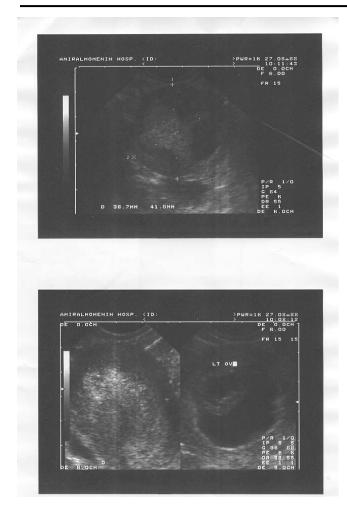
Sonographic view of isthmic ectopic pregnancy
